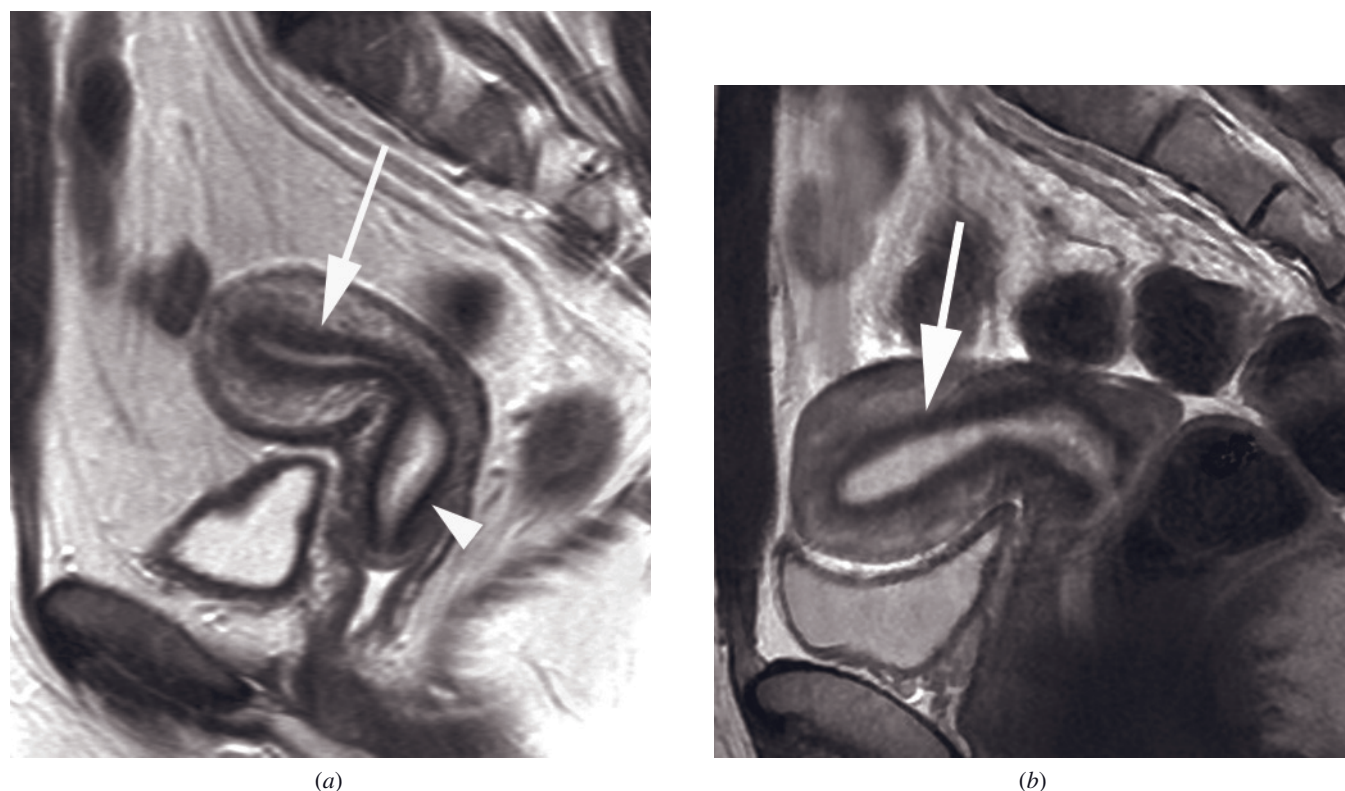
Zonal anatomy of the uterine corpus and cervix. (a) Sagittal T2-weighted ETSE image of the uterine corpus and cervix. The central hyperintensity in the uterine corpus represents the endometrium. The band of low signal intensity represents the junctional zone (arrow), which appears continuous with the fibrous stroma of the cervix (arrowhead). The outer layer of the myometrium is of intermediate signal intensity. Zonal anatomy of the uterine corpus and cervix at 3T. Sagittal T2-weighted ETSE image of the uterine corpus and cervix in a different patient (b) shows the myometrial layers including the junctional zone (arrow).
